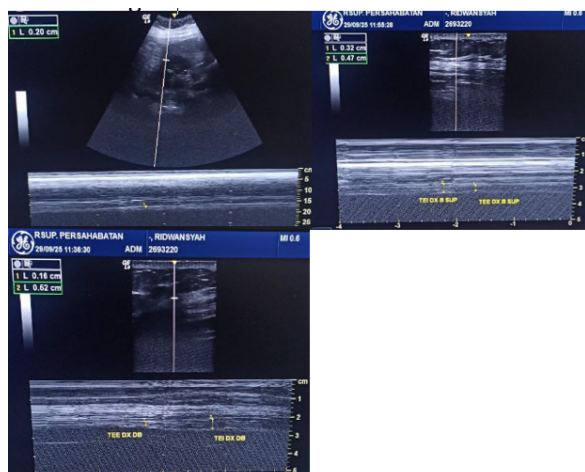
Case I: Diaphragm ultrasonography normal and functional diaphragm (29/09/25)
